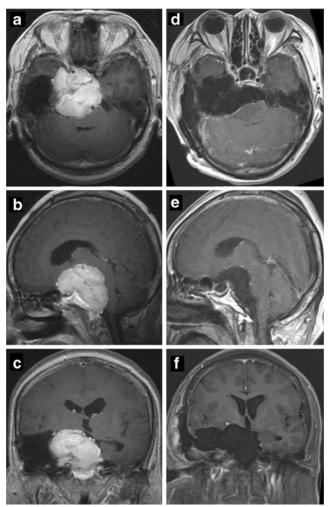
Case 2: pre- (a–c) and post-operative (d–f) magnetic resonance imaging. A 54-year-old female had previous surgery and gamma knife surgery at a local hospital with a preoperative KPS score of 70. Tumor size was  $5.6 \times 5.8 \times 6.4$  cm. A presigmoid approach was performed, and the tumor was completely removed. The patient's postoperative course was not uneventful: CNs III and VII defects, dysarthria, motor and swallowing dysfunction occurred. The patient's postoperative KPS score was 60. After 28 months, she was living with neurological defects but could perform household duties with a KPS score of 80. *CN* cranial nerve, *KPS* Karnofsky Performance Scale
